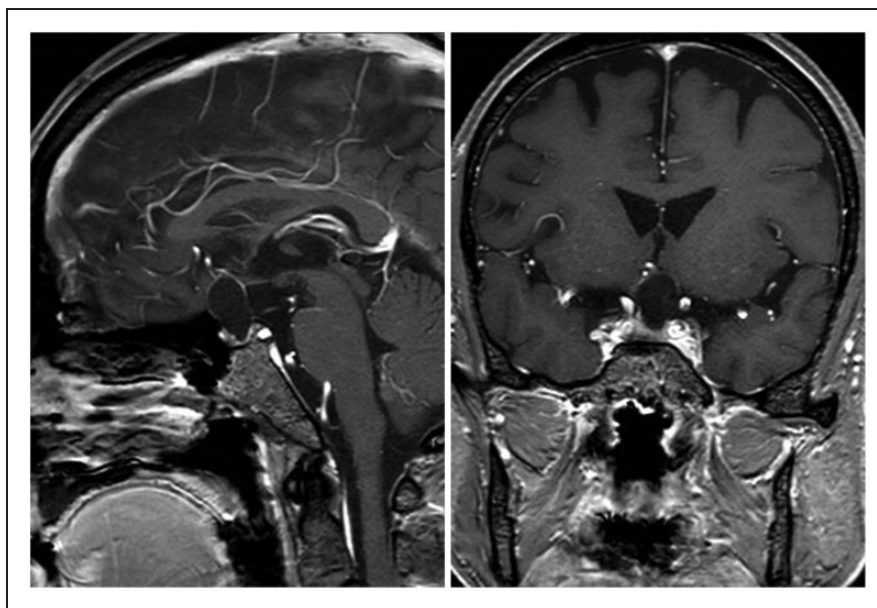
Preoperative contrast T1-weighted magnetic resonance imaging (left, sagittal view; right, coronal view) demonstrating an oval-like mass lesion extending from the sella turcica to the suprasellar space with the circuit of the tumor enhanced.
